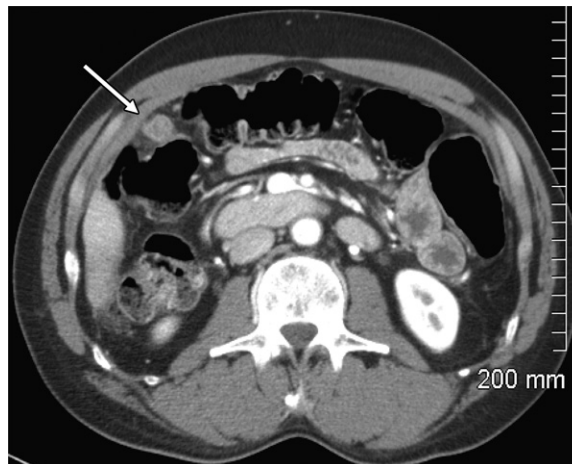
Missed peritoneal implants in a patient with a rising α -fetoprotein level after biopsy and percutaneous ablation for hepatocellular carcinoma (HCC). Axial contrast-enhanced CT image shows a peritoneal implant in the omentum (arrow), which was missed by the original interpreting radiologist. The interventional radiologist who performed the procedure noticed these implants and reviewed the case with the interpreting radiologist, who noted that he didn't realize that HCC could spread into the peritoneal space.
